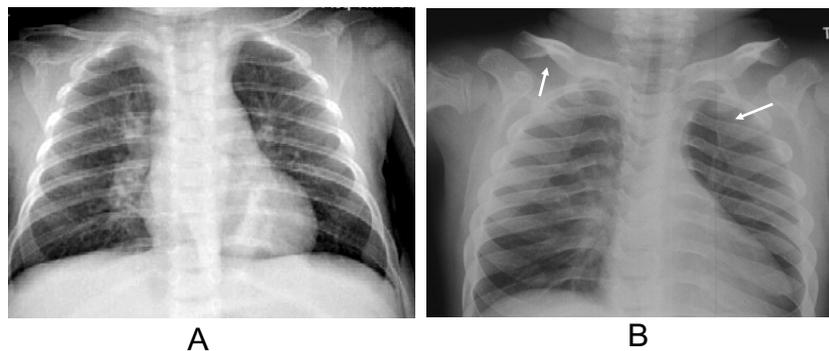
Manifestations of dysostosis multiplex in the thorax. Radiographs showing (A) a normal chest and (B) a chest of an MPS patient showing paddle-shaped ribs and short thickened clavicles (arrows).
